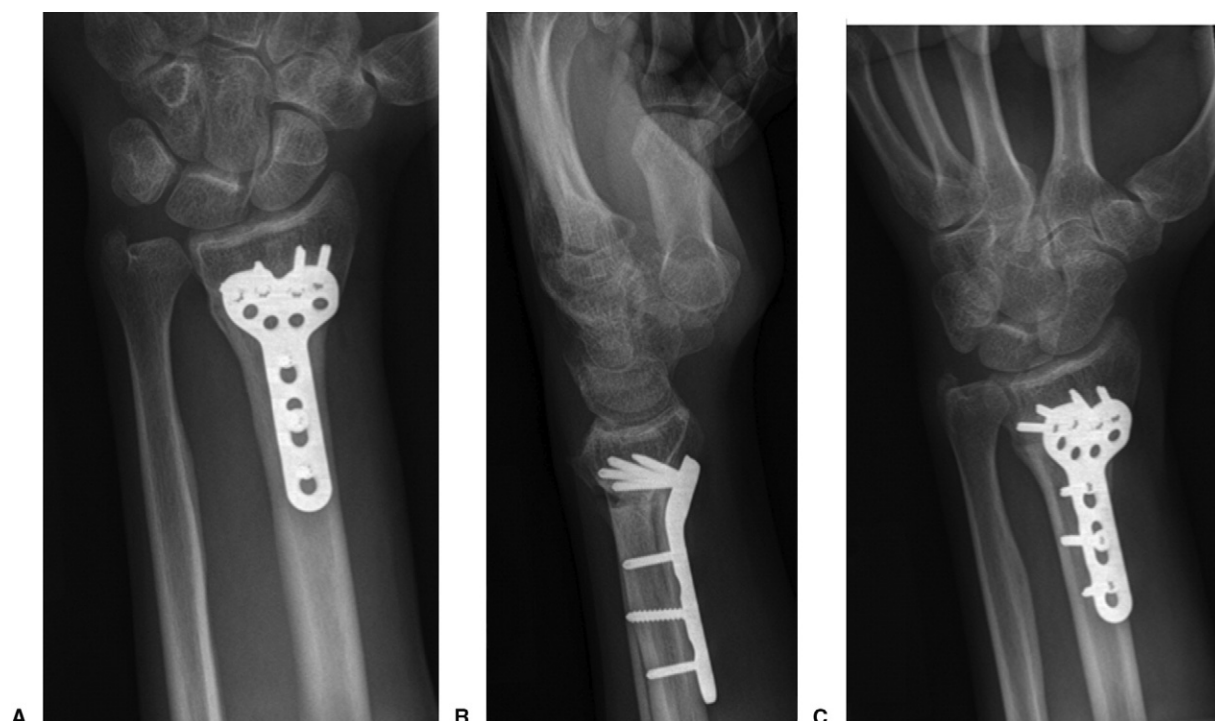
Four months after surgery, A anteroposterior, B lateral, and C oblique radiographs show bridging callus on the fracture site, best seen on the oblique view C.
